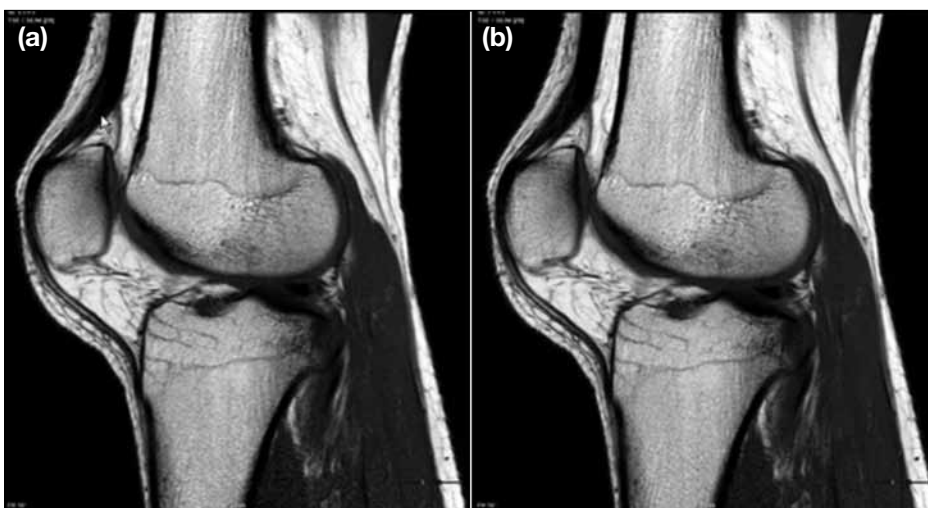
Sagittal T1-weighted fast spin-echo images acquired at 1.5 T (a) with and (b) without SENSE, with all other parameters being identical, showing a slightly lower signal-to-noise ratio in the image with SENSE. The whole scan time is 1:29 and 2:55 minutes, respectively.
